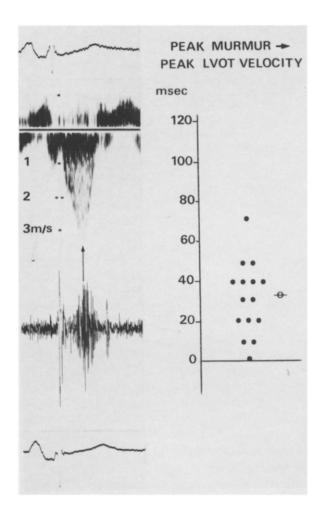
Correlation of continuous wave Doppler left ventricular outflow tract (LVOT) signal (top) with phonocardiogram (bot-tom). In the 15 patients with high quality Doppler and phonographic tracings, the peak velocities occurred a mean of 30 ms later than the maximal intensity murmur, with a range of 0 to 70 ms (right panel).
